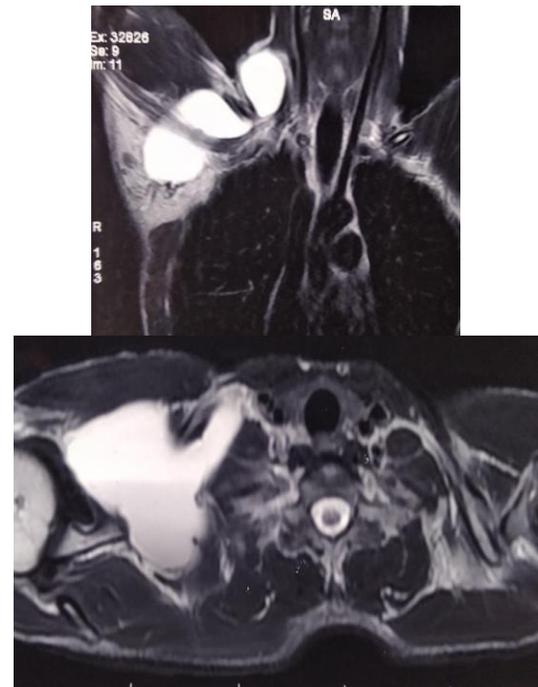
(b): CT scan and MRI showing non enhancing cystic lesion in right lower posterior cervical space, extending into infraclavicular space and axilla.
